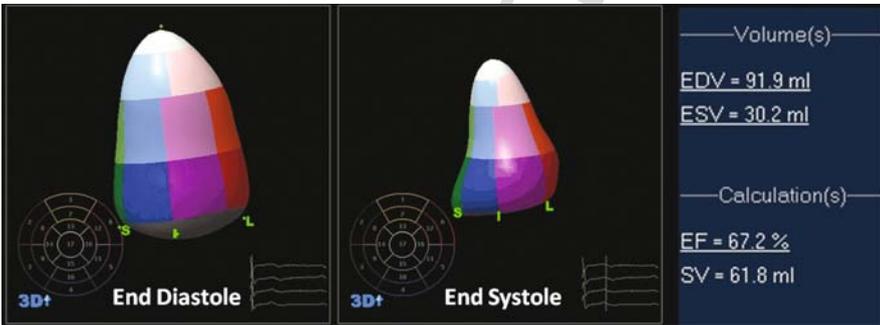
Calculation of left ventricular volumes and ejection fraction (EF) by three-dimensional echocardiography. A 3D ultrasound system calculates the end-diastolic volume (EDV), end-systolic volume (ESV), stroke volume (SV), and LVEF automatically from a 3D data set after an operator manually enters key reference points of the left ventricle
